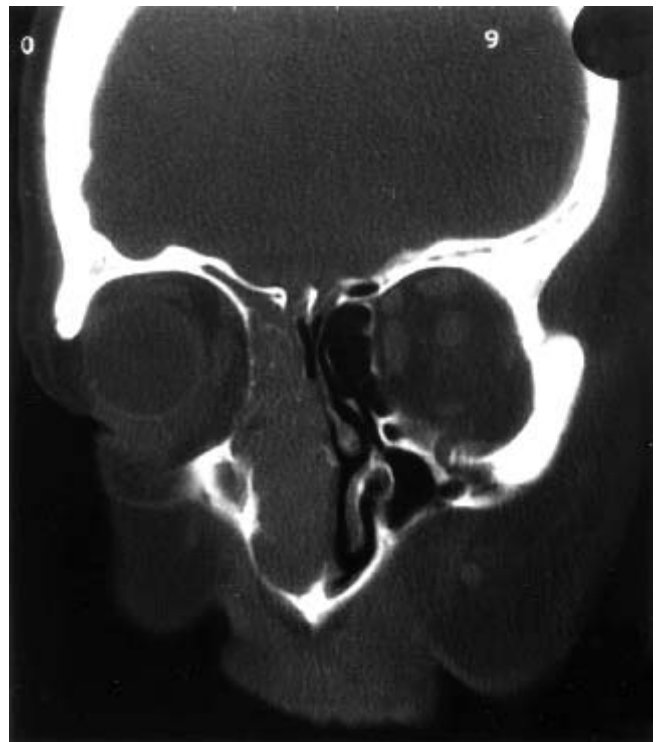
The coronar CT scan shows a complete obliteration of the right ethmoid cell system without destruction of the skull base bone or the medial orbital wall (arrow). The right middle turbinate is shifted towards the nasal septum. The entire right nasal cavity is obstructed and the nasal septum is bended to the left side.
